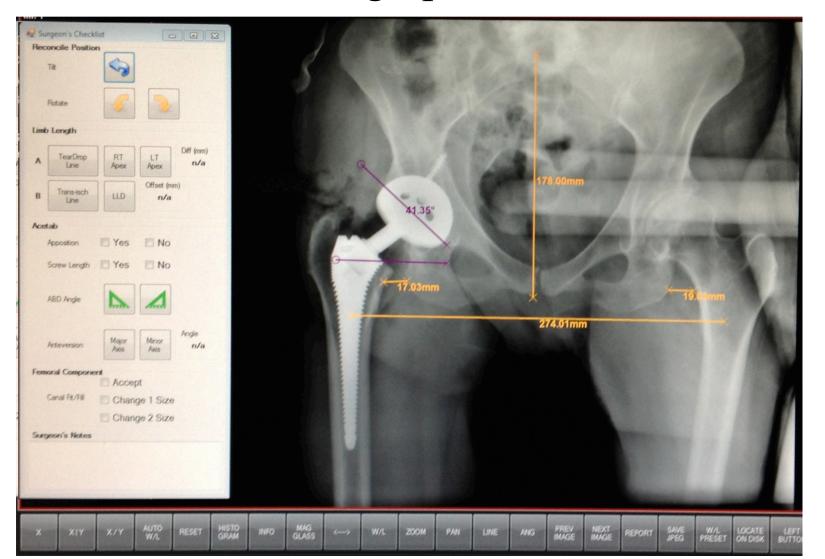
Digital intraoperative radiograph with surgeon's checklist and measured parameters
